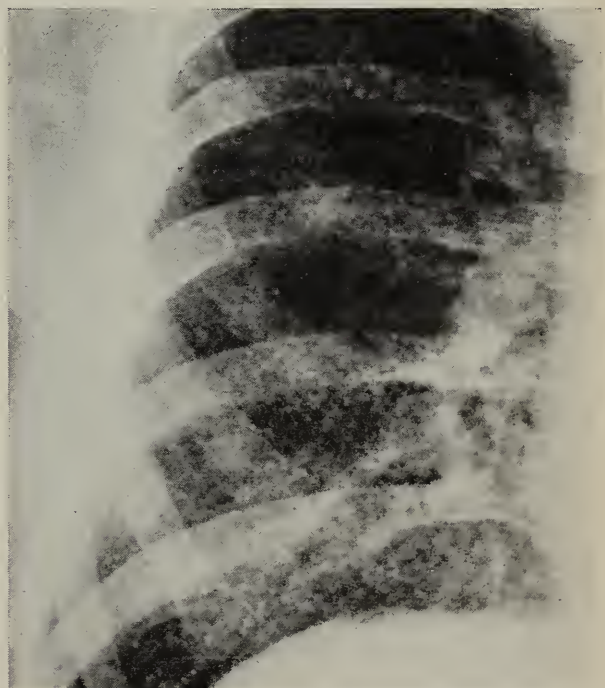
Detailed x-ray view of the right lower lobe of adult male with miliary tuberculosis. Note the uniform characteristics of the widespread discrete infiltrates.
